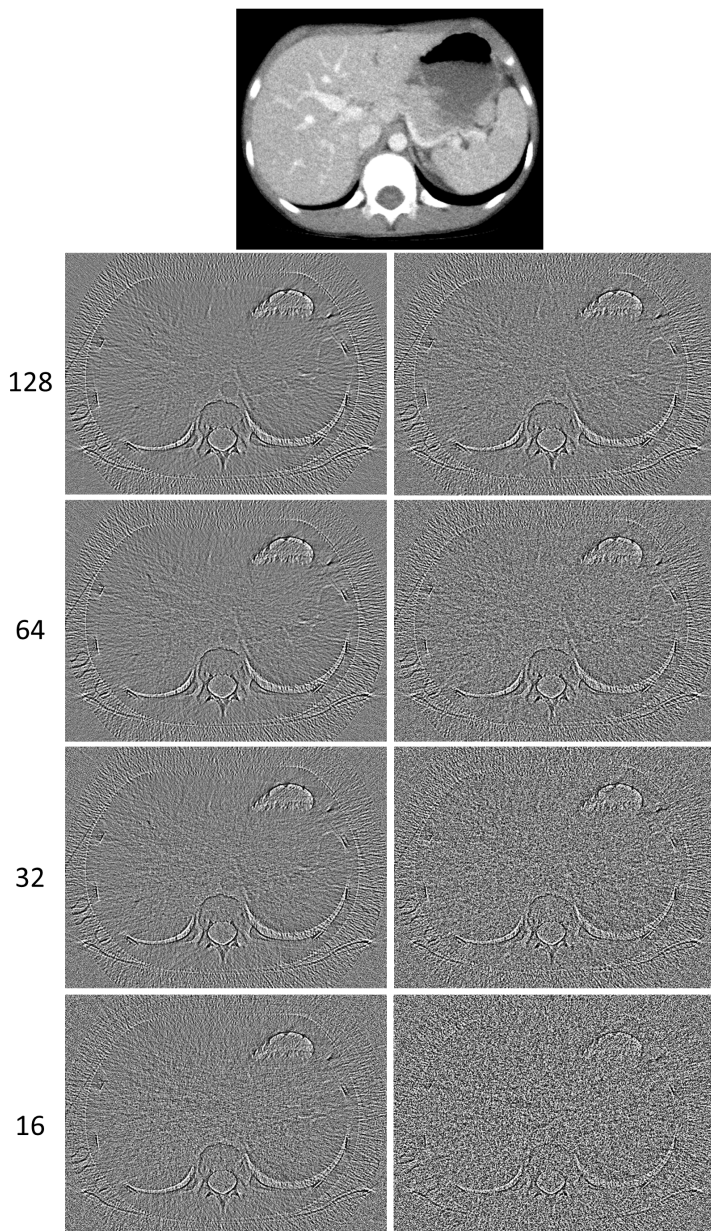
A typical CT abdomen image with added noise (top image), nonlinear distortion of object ( $NLD_{object}$ ; left column) and the approximated nonlinear distortion of object ( $NLD'_{object}$ ; right column) of the same image calculated using 128, 64, 32, and 16 images (top to bottom) respectively.
